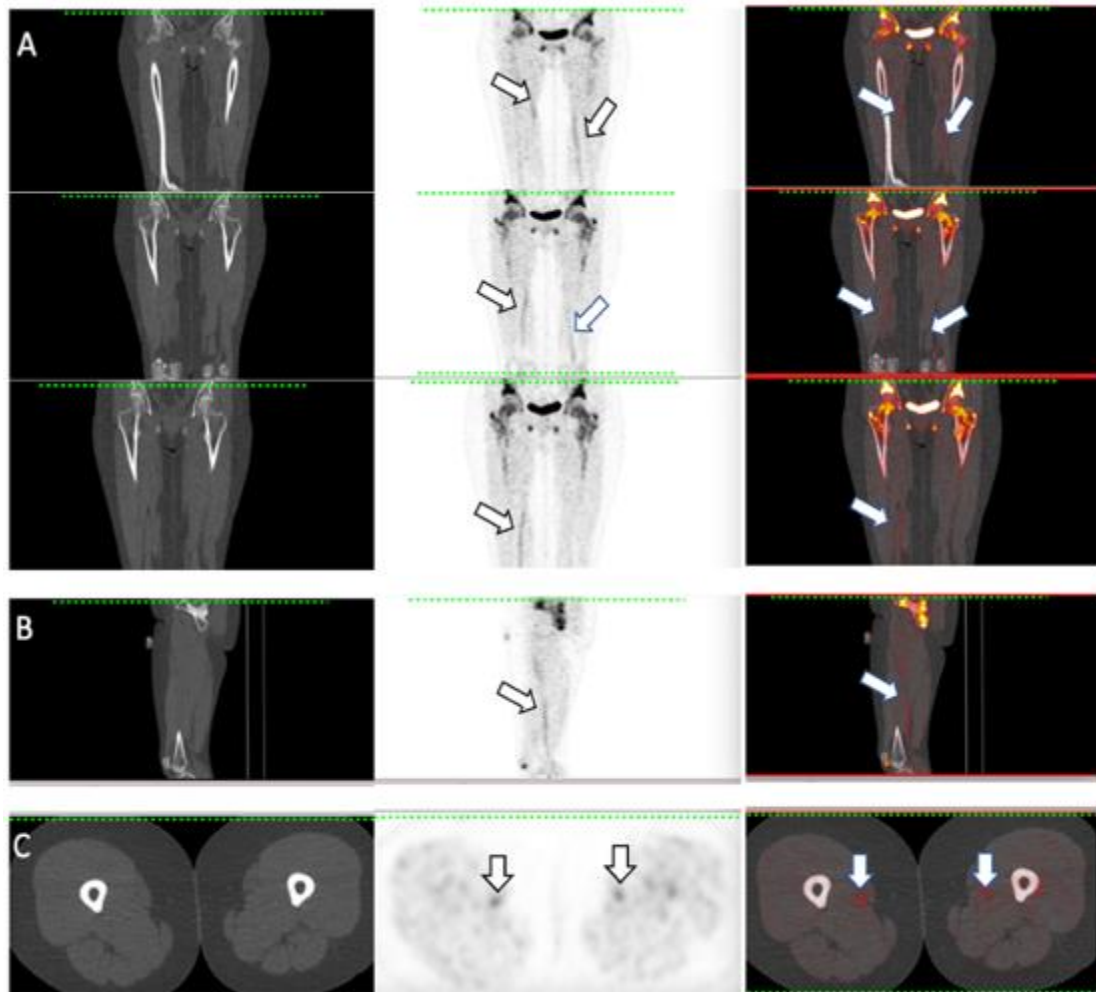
^{18}F -NaF PET/CT image for a 56 year old, female AKU patient, showing high activity in the thigh.
